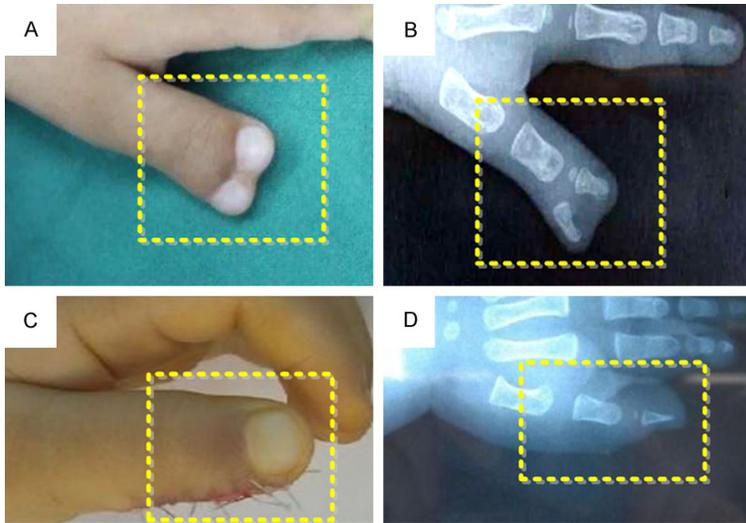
Visual and X-ray images of the affected area of a child before and after surgical treatment. Note: A: Visual image before surgery; B: X-ray image before surgery; C: Visual image after surgery; D: X-ray image after surgery; the affected area was shown in the dotted box.
